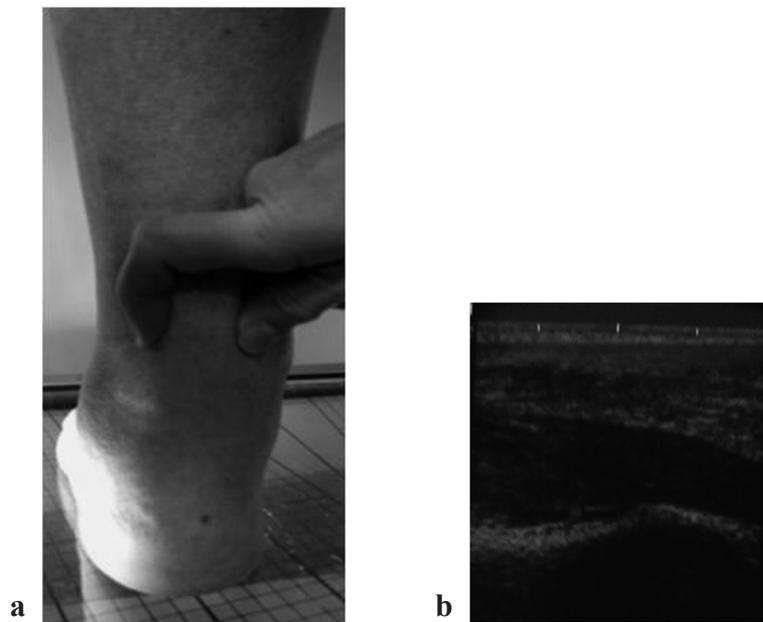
A) Achilles tendon with clinical peritendinous edema and thickening in symptomatic patient. B) Ultrasound exam of Achilles tendon with peritendinous edema and thickening in symptomatic patient.*
